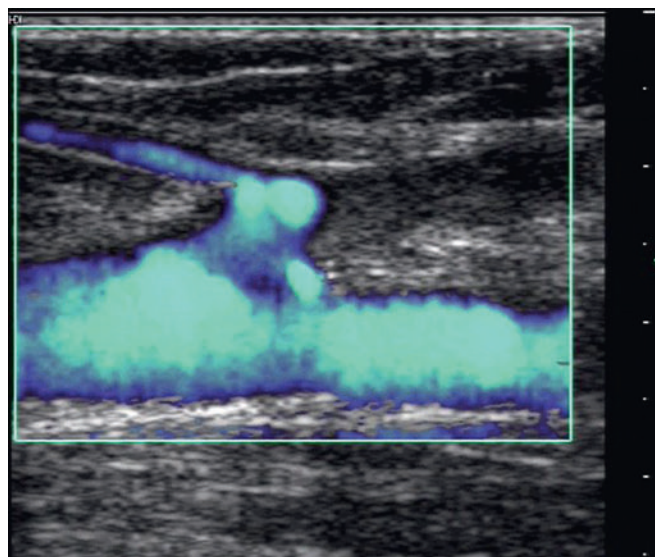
Duplex ultrasound. Physiological drainage of the superficial epigastric vein in the stump of the saphenofemoral junction after radiofrequency ablation. (From Perrin M. *Traitement chirurgical endovasculaire des varices des membres inférieurs. Techniques et résultats*. EMC [Elsevier Masson SAS, Paris], Techniques chirurgicales—Chirurgie vasculaire, 43-161-C, 2007).
